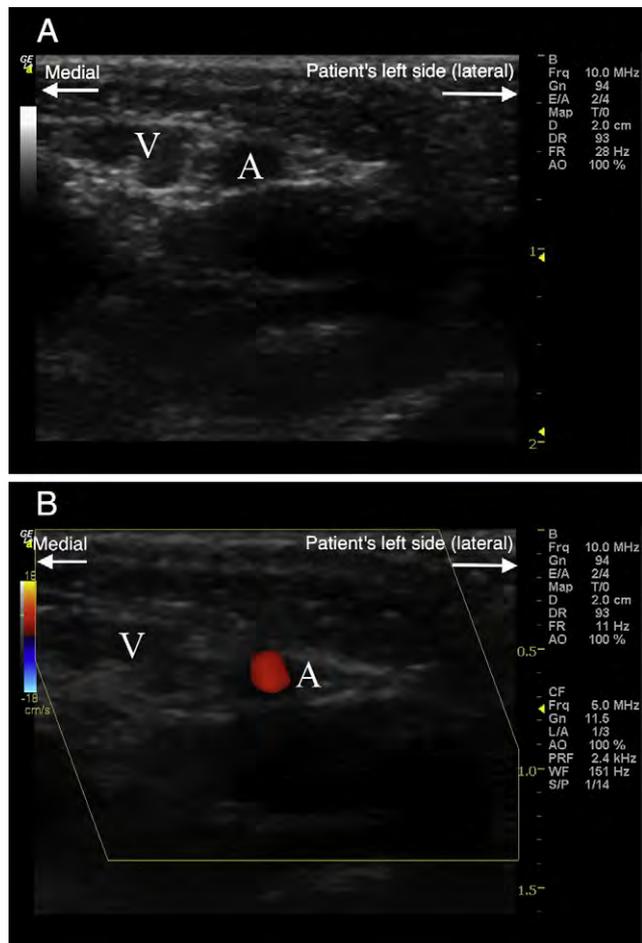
(A) Left femoral vessels in a 3-kg neonate demonstrating the small size of the FV (V) and femoral artery (A). (B) Color flow Doppler demonstrating a velocity signal in the femoral artery (A) and FV (V). The sonographer is positioned at the patient's lower extremities and facing cephalad. Note depth scale along side of image: 2.0 cm for 2D image and 1.5 cm for color Doppler image.
